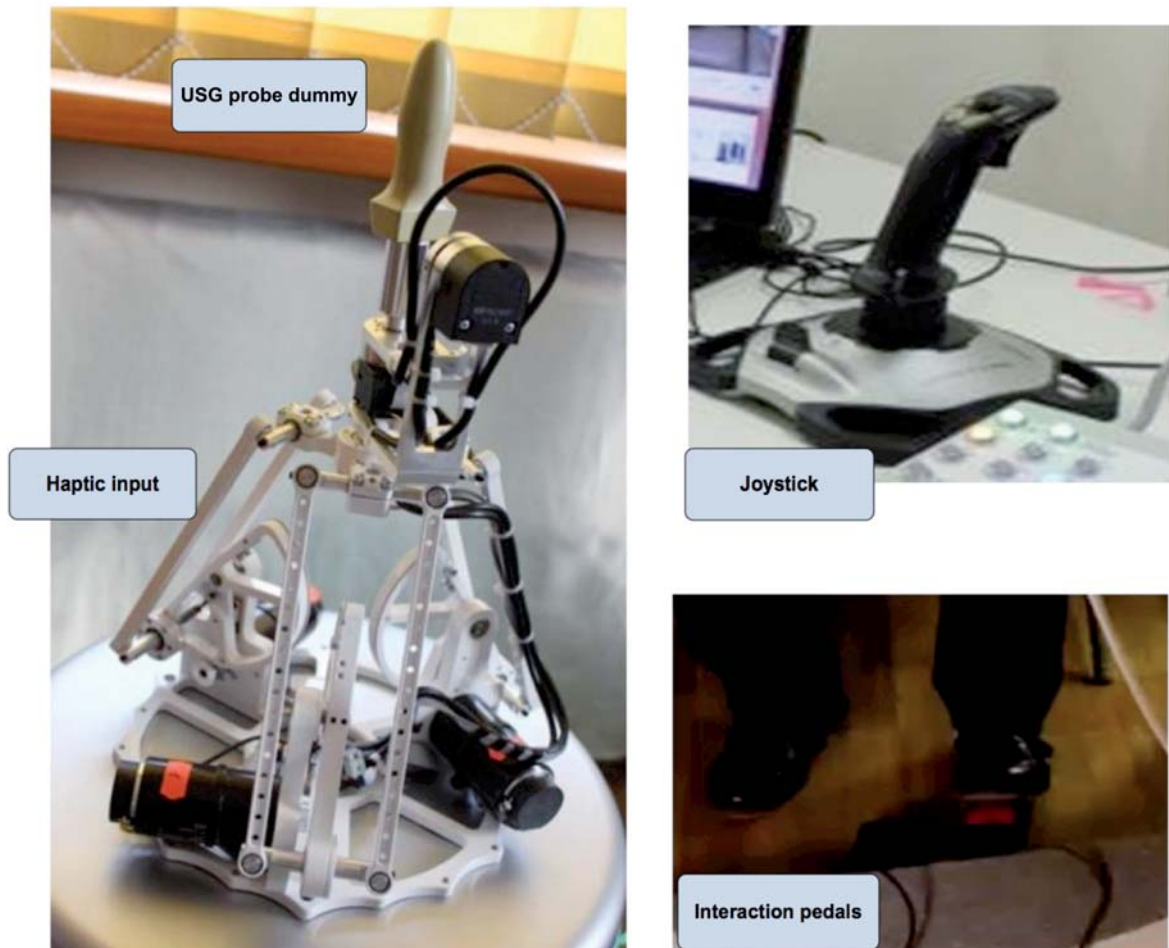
Hardware components required for the ultrasonographic examination on the diagnostician site
